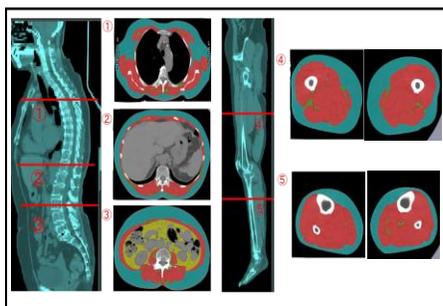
Whole body CT scan analysis
